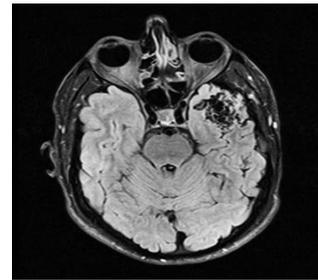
Axial MRI T1 weighted image shows AVM in the left cerebral hemisphere
